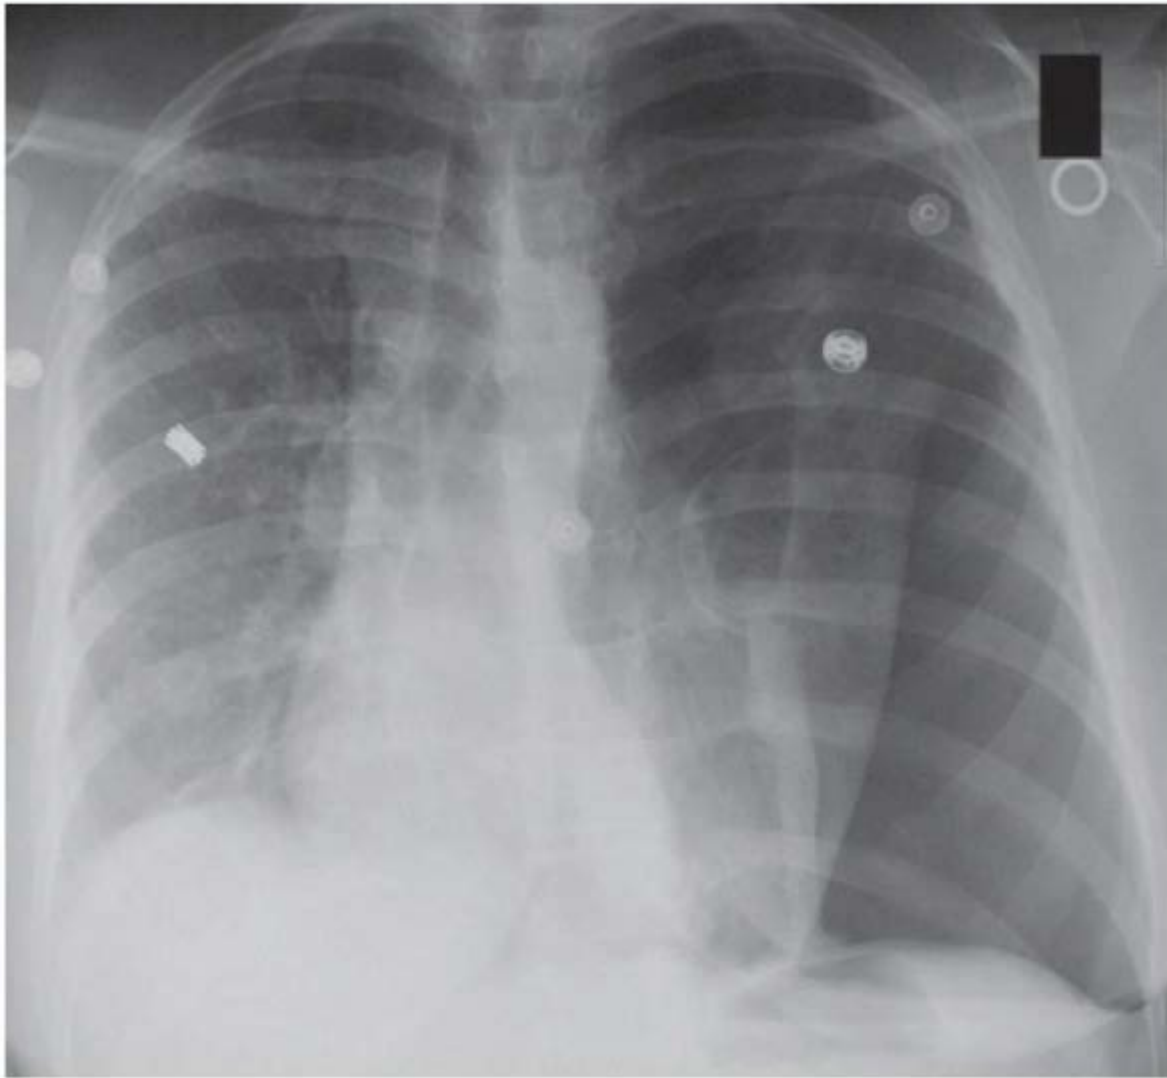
Plain chest x-ray of a patient with tension pneumothorax demonstrates deviation of the trachea and shift of the mediastinum away from the side of the tension. Depression of the ipsilateral hemi-diaphragm is also noted. (Photo courtesy of open access clinicalcases.org CC-BY-SA-2.5)
